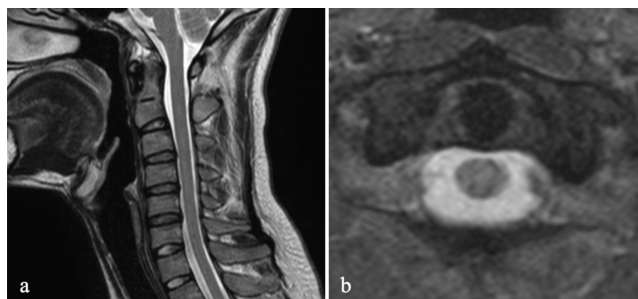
2B. Post-reduction magnetic resonance imaging of case 1 shows intact transverse and alar ligaments and no spinal cord lesions. (2A) Sagittal view. (2B) Axial view of odontoid process.
